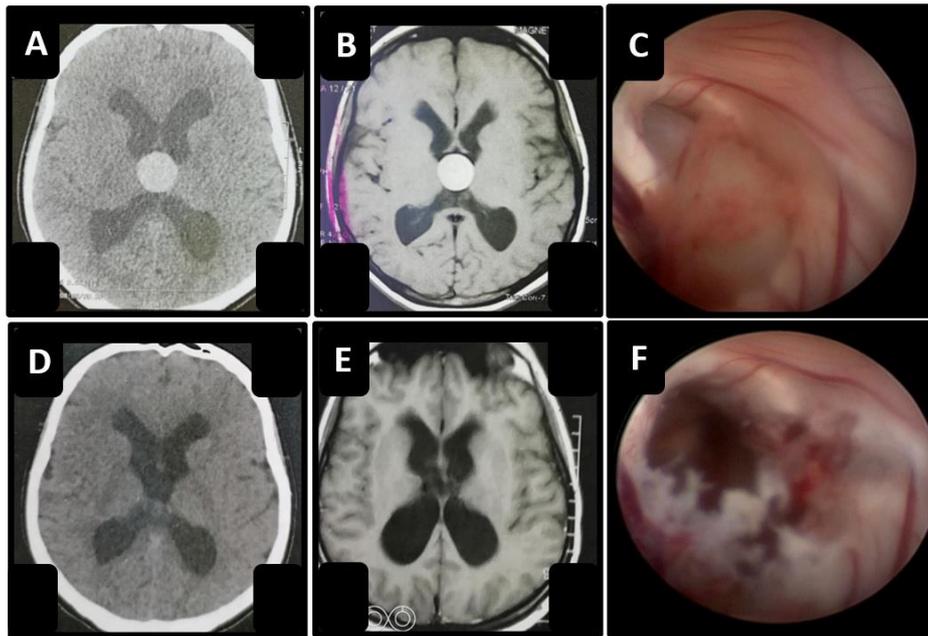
28 years old female patient presented with headache and blurring of vision, her fundus examination revealed papilledema. Complete resection was done endoscopically with postoperative improvement of her symptoms with resolution of papilledema. (A) preoperative CT scan shows hyperdense colloid cyst associated with hydrocephalus, (B) the lesion is hyperintense in MR T1-weighted images. (C) Endoscopic view shows the cyst before resection. (D, E) CT and MR images shows complete excision of colloid cyst. (F) Endoscopic view after gross total resection
